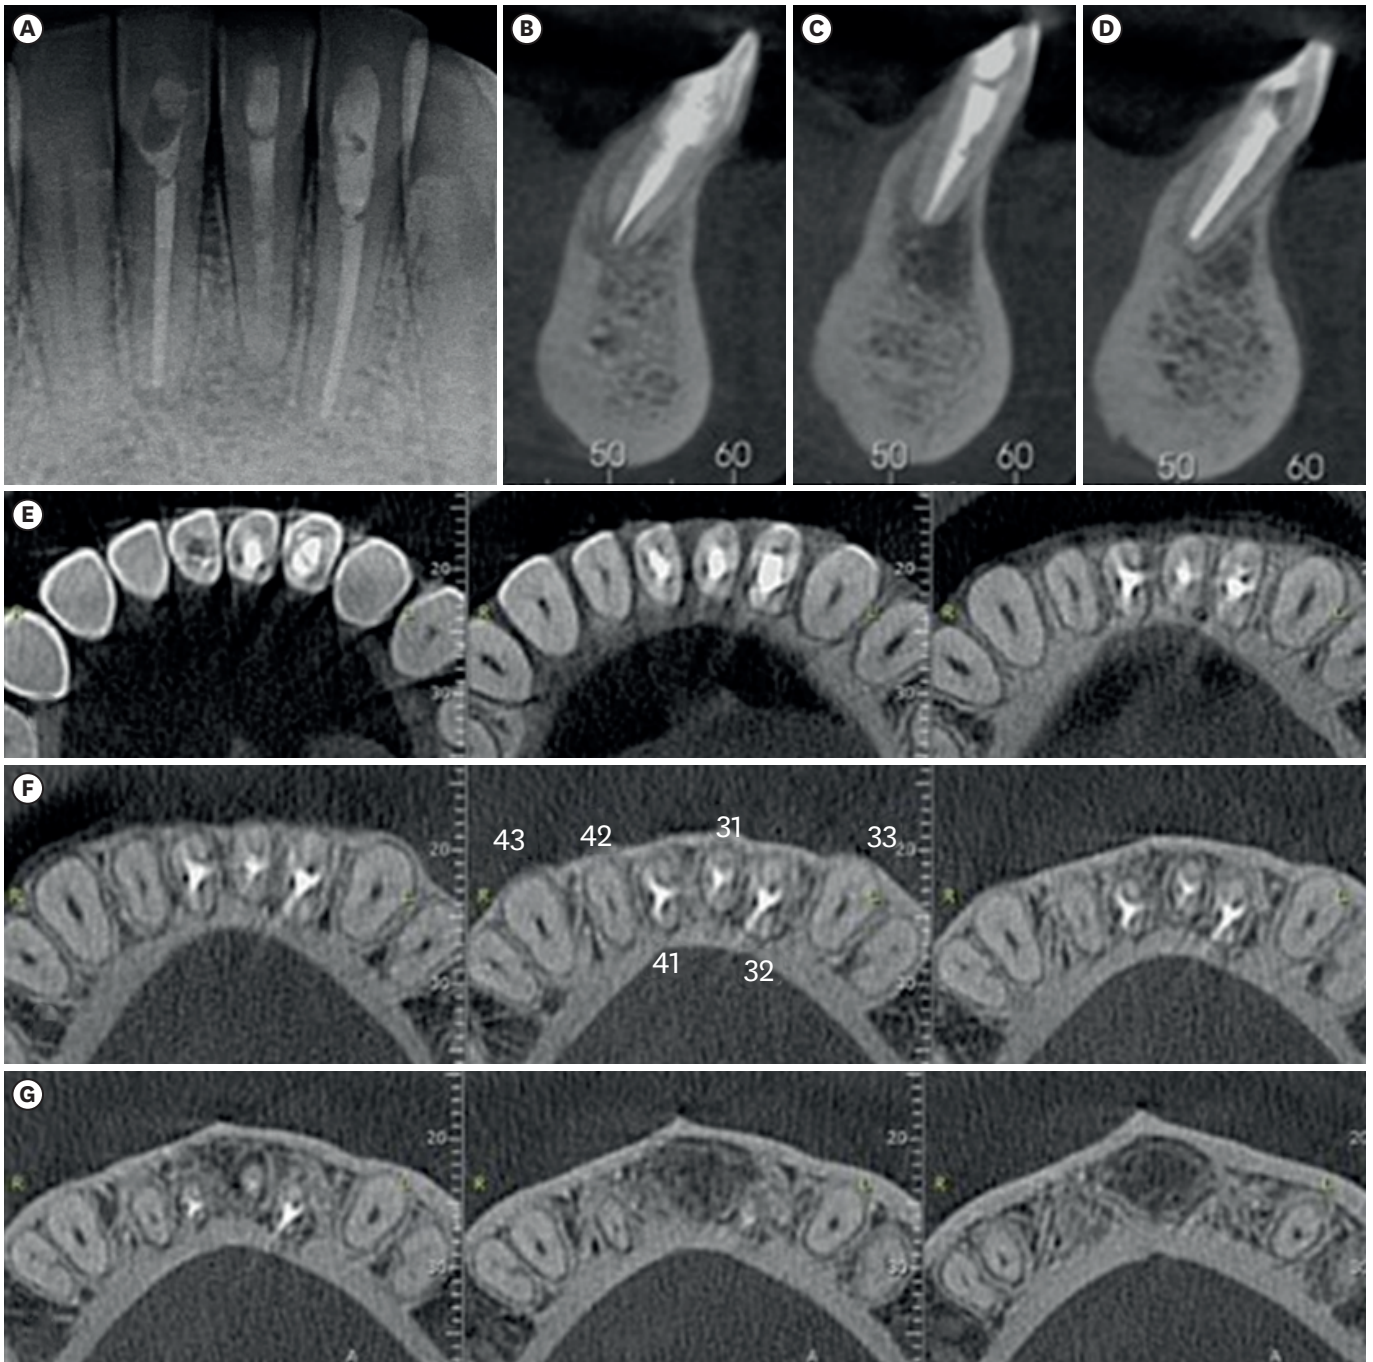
Images referring to the first follow-up. (A) 6-month follow-up radiography. (B and D) Cone-beam computed tomography (CBCT) images (sagittal views) of teeth (B) #32, (C) #31 and (D) #41 with evidence of the apical repair process. (E-G) CBCT images (axial views), (E) cervical, (F) middle, and (G) apical sections with evidence of the apical repair process and decreased lesion size.
